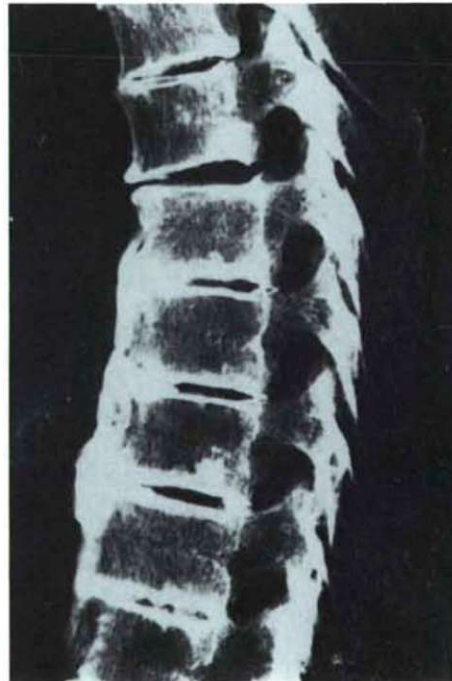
Lateral X-ray of the spine belonging to
